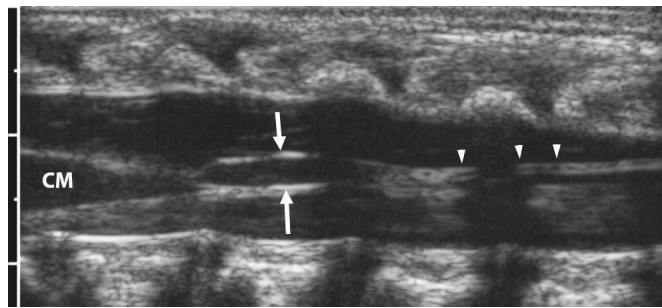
Filar cyst. Spinal canal. Ultrasound. Longitudinal plane. Midline. Level of the filum terminale. There is a cyst (arrows) within the dorsal aspect of the upper portion of the filum (arrowheads). The filar cyst is seen just below the conus medullaris (CM).
